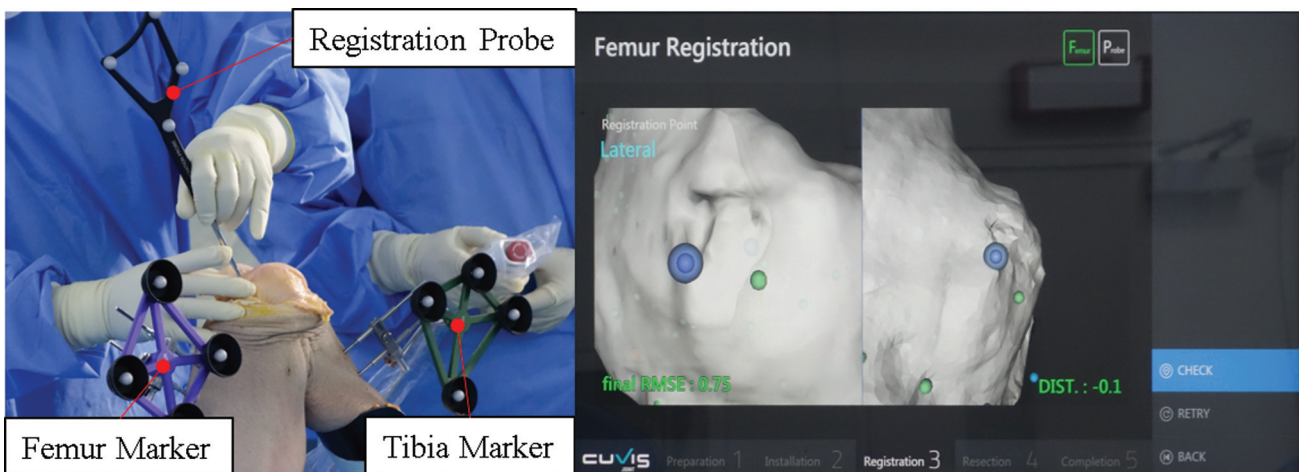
The agreement of the operated knee with the virtual model developed from the CT images was assessed by probing. When a probe was placed on distal portion of medial femoral condyle, the difference between the operated knee and the virtual knee was presented on the main console.
